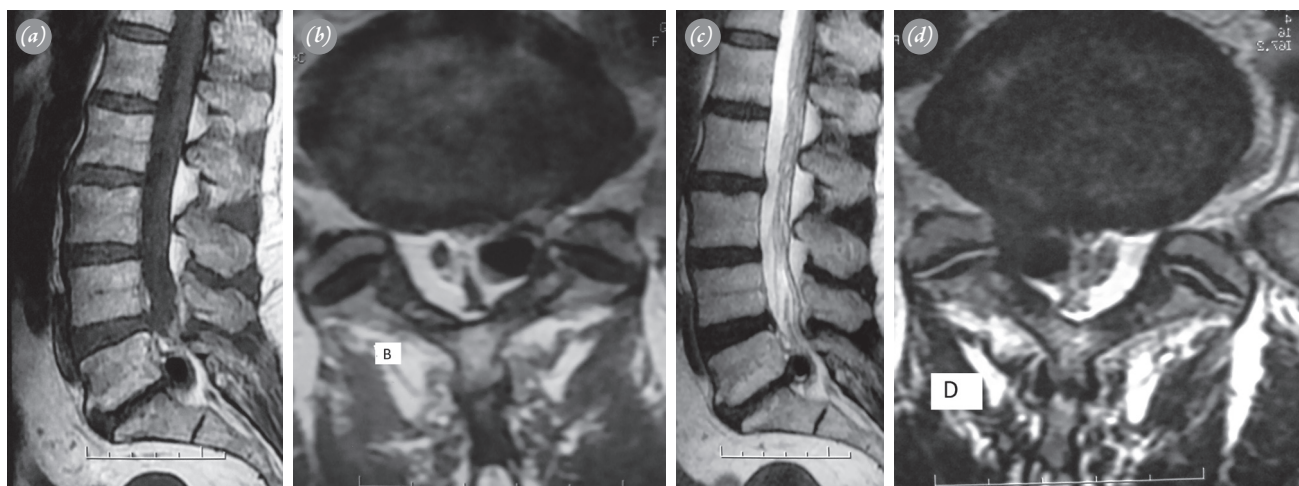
(a) Sagittal and (b) axial T1-weighted images showing the vacuum disc phenomenon and hypointense cystic mass in the spinal canal. (c) Sagittal and (d) axial T2-weighted images showing the hypointense cystic mass compressing the left L5 root.
